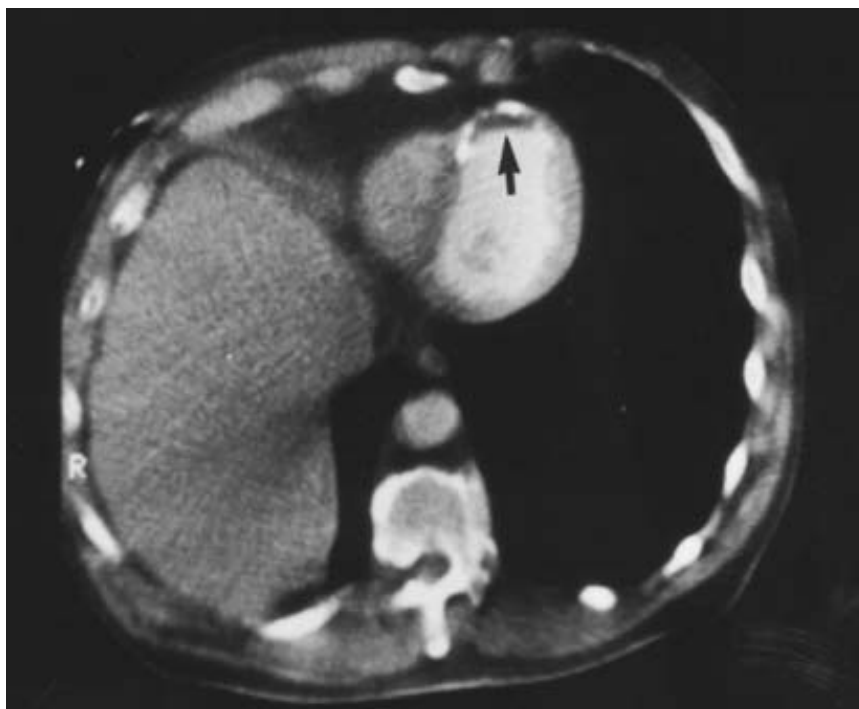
A single frame from a contrast-enhanced cine CT scan demonstrates thrombus in a LV aneurysm. Also note that the wall of the aneurysm is calcified.
